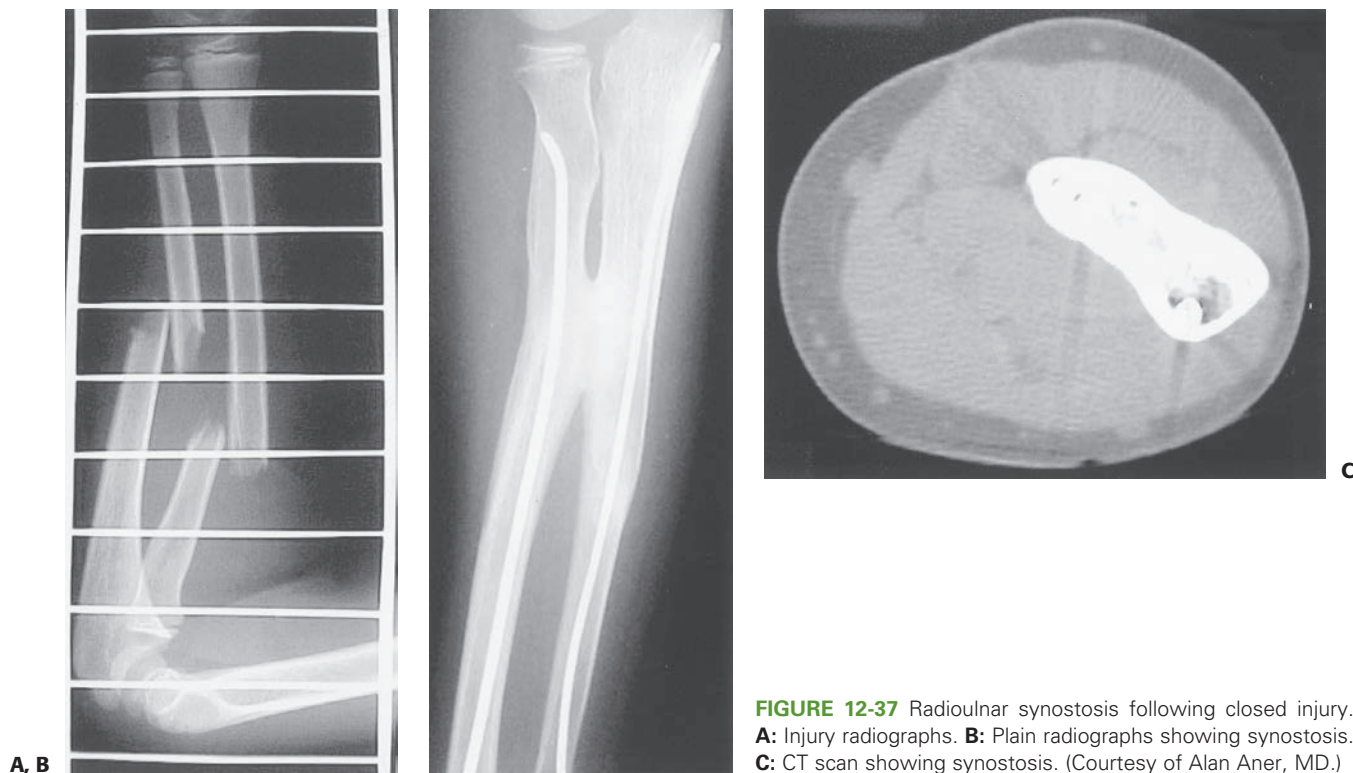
Radioulnar synostosis following closed injury. A: Injury radiographs. B: Plain radiographs showing synostosis. C: CT scan showing synostosis. (Courtesy of Alan Aner, MD.)
